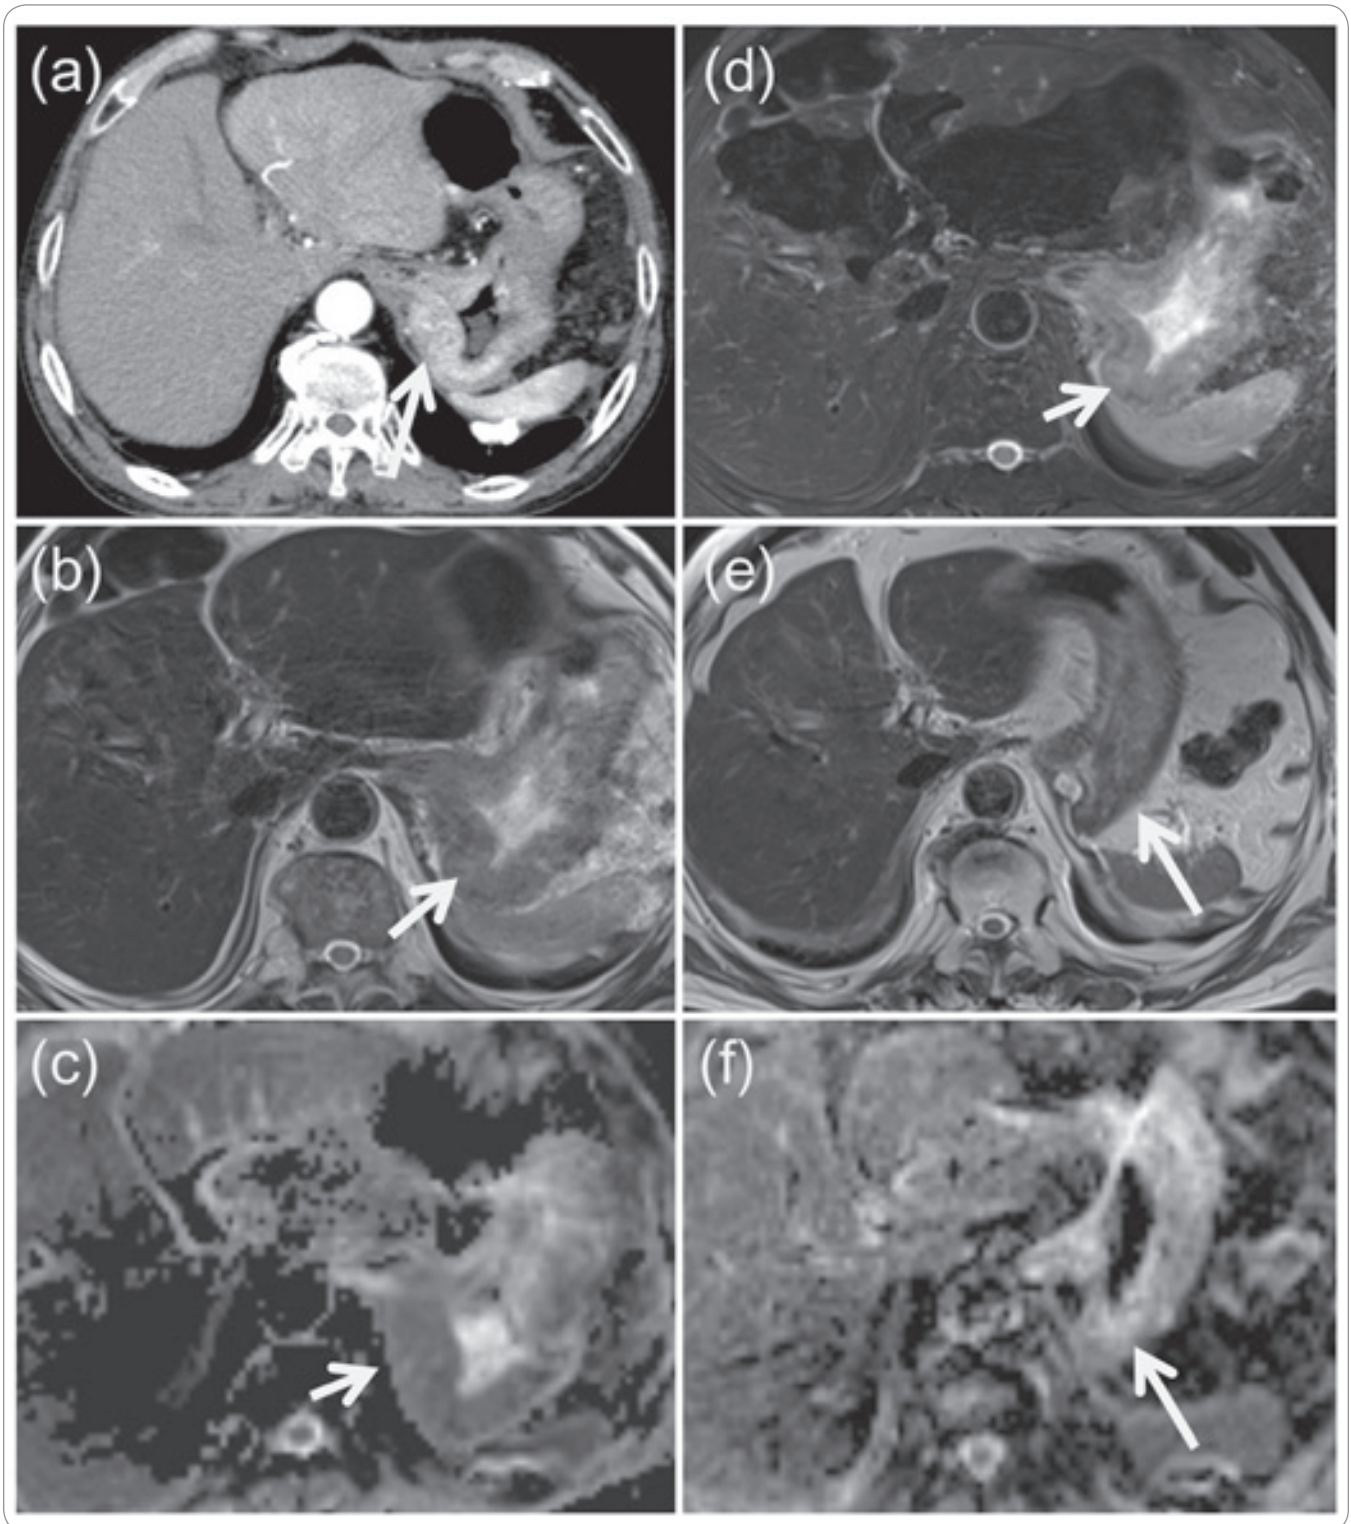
CT and MRI findings. Contrast-enhanced CT prior to concurrent chemoradiotherapy showed thickening of the posterior gastric wall and strong contrast enhancement (arrow) (a); T2-weighted fast spin echo image showed that the posterior wall of the stomach was thickened with a hyperintense irregular mass (arrow) relative to the liver parenchyma (b); the apparent diffusion coefficient map generated from diffusion-weighted imaging at a b-value of 800 s/mm² showed that the gastric tumor (arrow) was hypointense compared to the skeletal muscle (c); T2-weighted fast spin echo image 6 years after radiotherapy showed complete disappearance of gastric tumor (arrow) with no evidence of metastasis (d); the apparent diffusion coefficient map generated from diffusion-weighted imaging at a b-value of 800 s/mm² 6 years after radiotherapy showed that the gastric tumor disappeared completely (arrow) (e).
